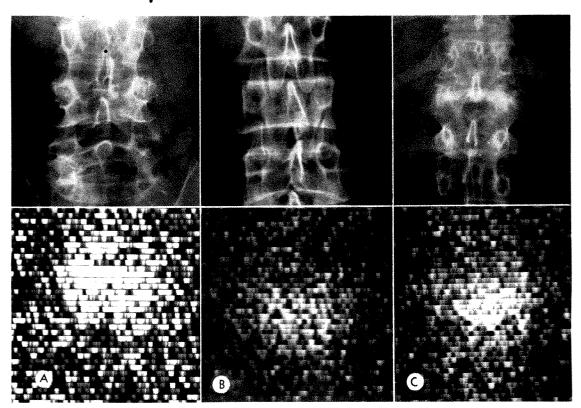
Similar scintigraphic findings caused by 3 different pathologic lesions. (A) Fracture of the fourth lumbar vertebra in a 65 year old man. (B) Paget's disease of the third lumbar vertebra in a 53 year old man. (C) Metastasis to the first lumbar vertebra from a primary carcinoma of the breast in a 49 year old woman
